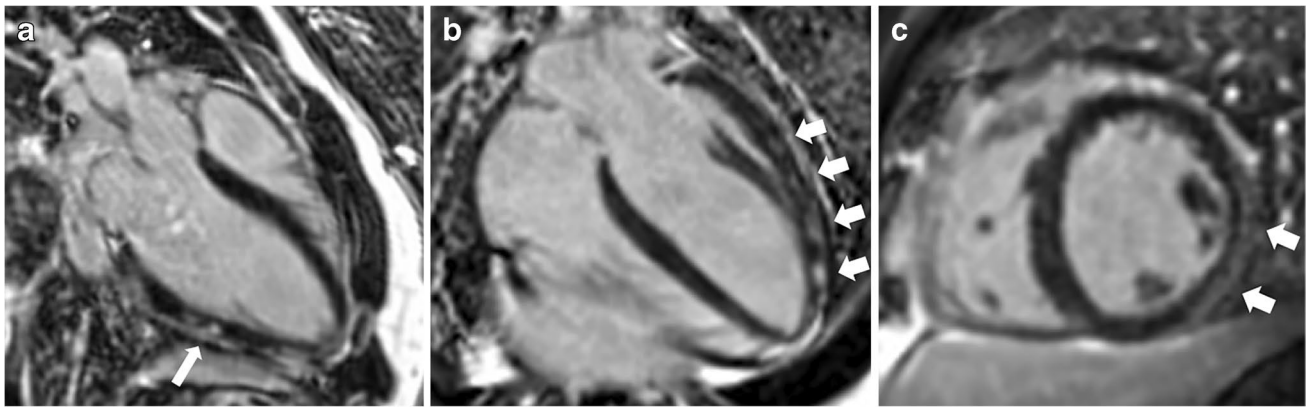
Cardiovascular MRI in a 15-year-old boy, patient 4. a–c Late gadolinium enhancement images show patchy subepicardial/mid-wall fibrosis in the basal-to-apical lateral wall in keeping with a previous
